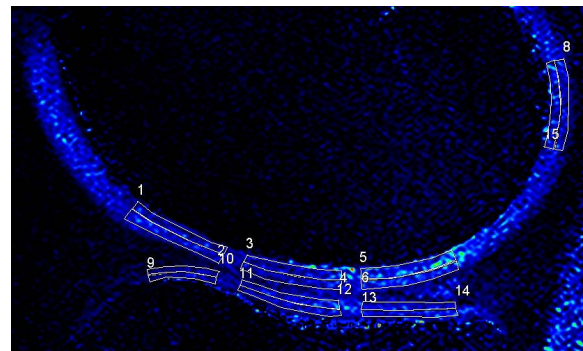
Sagittal T1Gd (dGEMRIC) MR image with 7 different cartilage zones (4 femoral, 3 tibial) and 14 ROIs.
